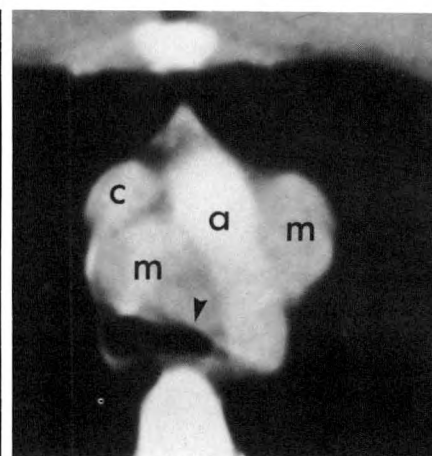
26-year-old man with increasing cough and wheezing. Contrast-enhanced CT showing an inhomogeneous, hypervascular, enhancing mediastinal mass (m) with its center on the aorticopulmonary region. Posterior displacement and narrowing of carina and left main bronchus (arrowhead). a = aorta; c = superior vena cava. An aortogram confirmed hypervascularity of mass.
